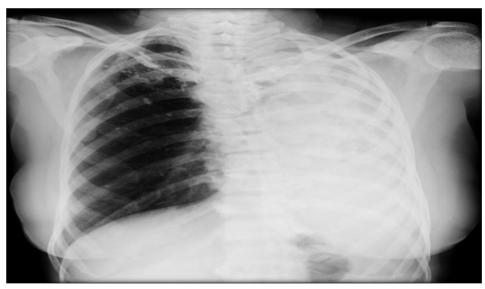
Chest radiograph showing unilateral lung destruction on left side with parenchymal calcifications on right side
